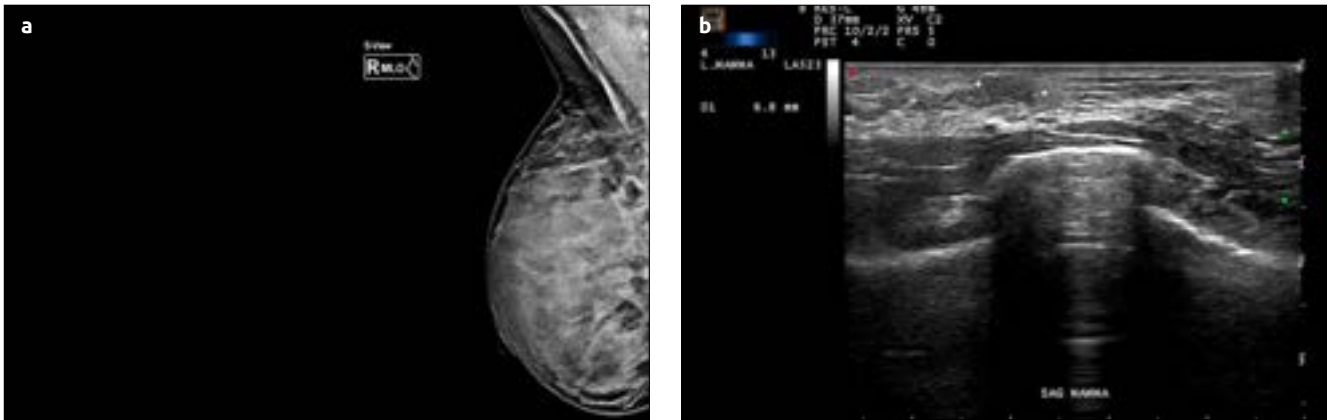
a, b. Right MLO Mammography images. No mass is seen (a). A hypoechoic lesion with well-defined borders is seen on sonography compatible with BI-RADS 3 lesion (b)
